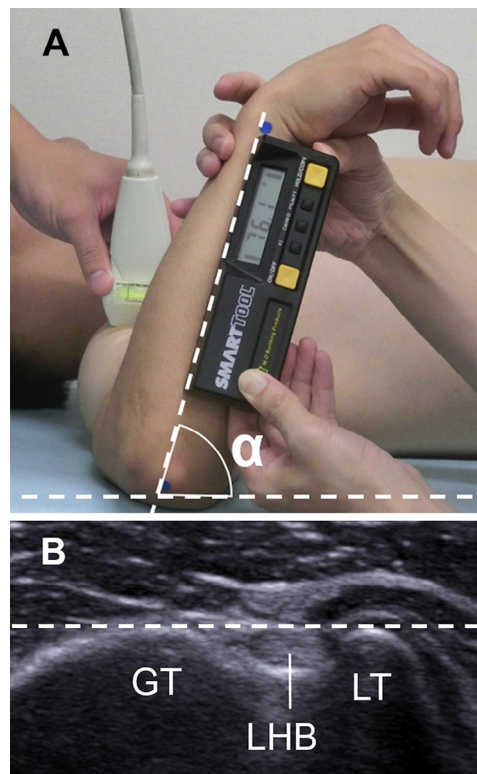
Assessment of humeral torsion angle (HTA). (A) Subjects lay supine with 90° of shoulder abduction and 90° of elbow flexion. A linear array ultrasound transducer was placed on the anterior aspect of the subject's shoulder. A digital inclinometer was placed on the ulna and recorded the forearm inclination angle with respect to the horizontal line (this angle α represented HTA). ●, Olecranon and distal end of ulna. (B) Echogram used for HTA measurement. The subject's humerus was passively rotated so that the line passing the apices of the greater and lesser tuberosities would be horizontal on the screen. GT, greater tuberosity; LT, lesser tuberosity; LHB, long head of biceps.
